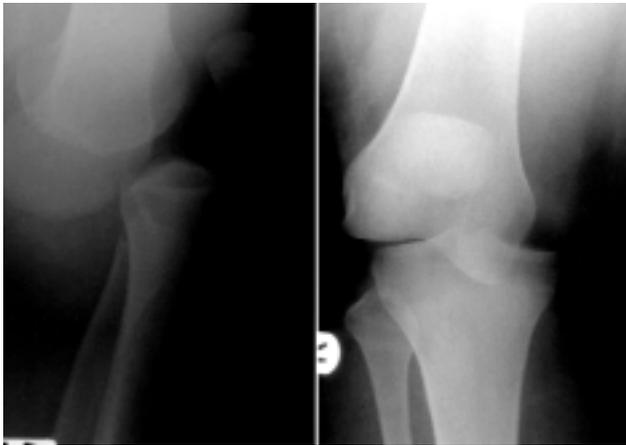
Radiographs showing anterior dislocation of the knee.
